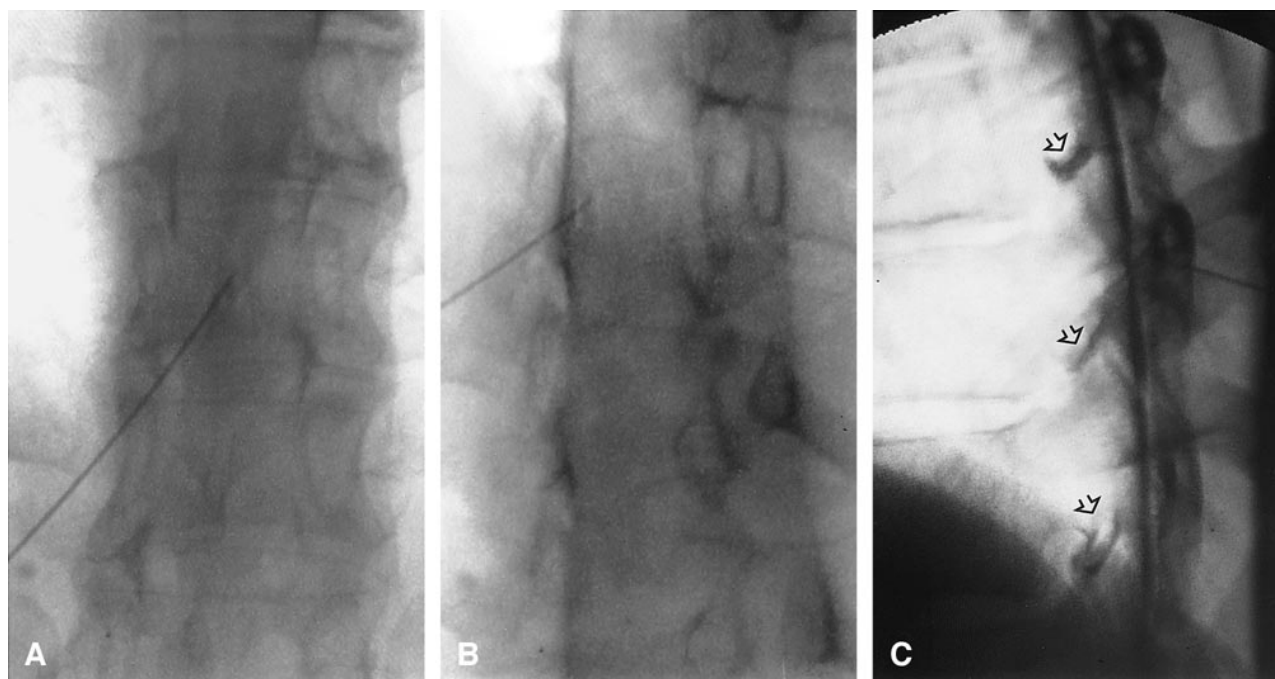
A–C, Anteroposterior (A), oblique (B), and lateral (C) radiographs after thoracic interlaminar epidural injection of contrast material reveal opacification of the lower thoracic epidural space dorsally before injection of steroid and local anesthetic. The Whitacre needle tip is in the midline within the posterior epidural space. Contrast material is seen extending along the proximal thoracic nerve sheaths (arrows).
